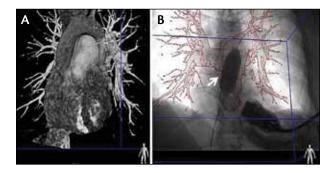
C-arm CT imaging with live fluoroscopy overlay during pulmonary valvuloplasty. Panel A shows the 3D volume rendering of the entire heart and great vessels. Panel B shows the extracted surface of the right ventricular outflow tract and pulmonary artery with fluoroscopic overlay. The outline of the pulmonary artery from the 3D volume rendering is all that is used for the overlay allowing the operator to optimize balloon positioning (white arrow). Reproduced with kind permission from Springer Science+Business Media: Int J Cardiovasc Imaging, Potential role of three-dimensional rotational angiography and C-arm CT for valvular repair and implantation, 2011;27:1205–1222, Schwartz JG, Neubauer AM, Fagan TE, et al.²⁷
